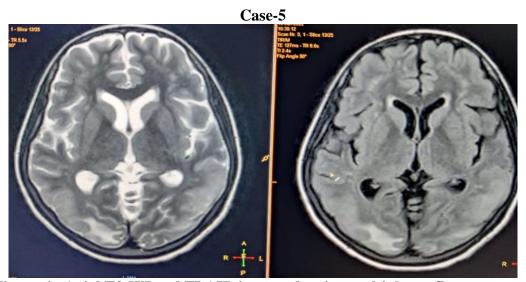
Axial T2-WI and FLAIR images showing multiple confluent areas of T2/FLAIR hyperintensities noted in bilateral parietal lobes, bilateral frontal lobes and bilateral occipital lobes-combination PRES
